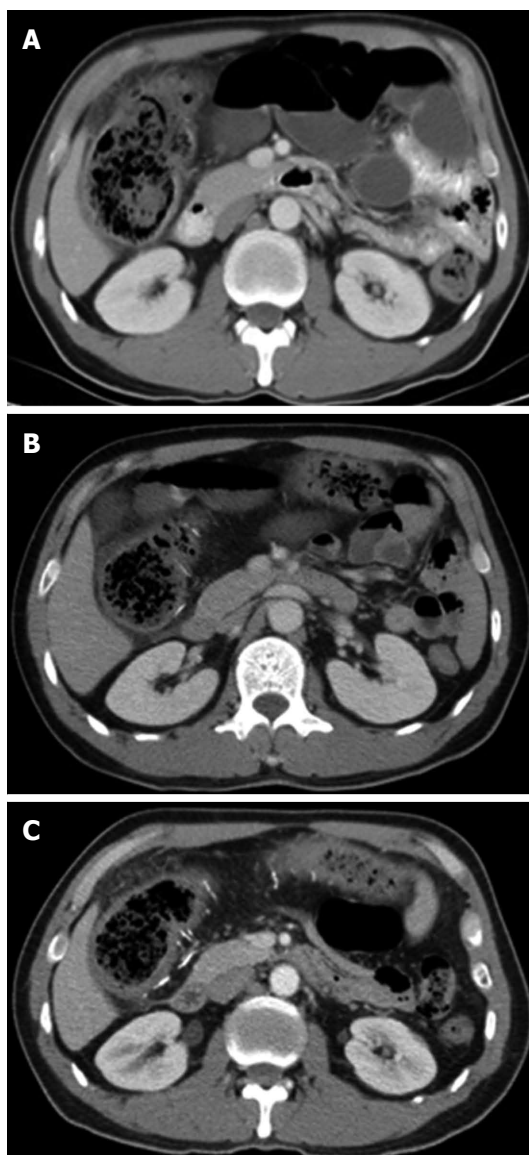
Serial computed tomography studies from 2005 to 2012. A 46-year-old male suffered from recurrent abdominal pain and severe constipation for about 10 years. A: Computed tomography (CT) study done on November 18, 2005 revealed dilated ascending colon and minimal colonic wall thickening without evidence of mesenteric venous calcification; B: CT study of the same case done on November 17, 2009 showed some linear calcifications at colonic wall. Dilated ascending colon with wall thickening was also noted; C: CT study of the same case done on January 3, 2012 showed more linear calcifications at colonic wall and mesenteric veins. The extent of colonic wall thickening was also more prominent in this study.
